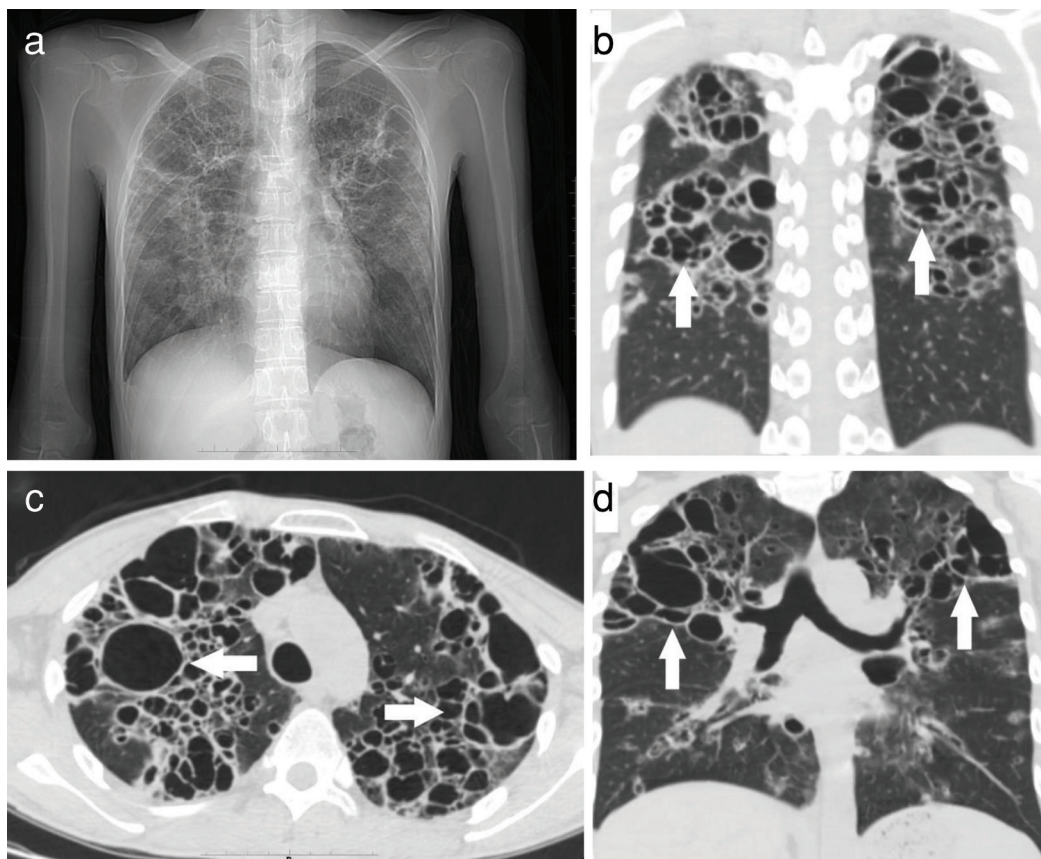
X-ray and CT manifestations of bronchiectasis.
